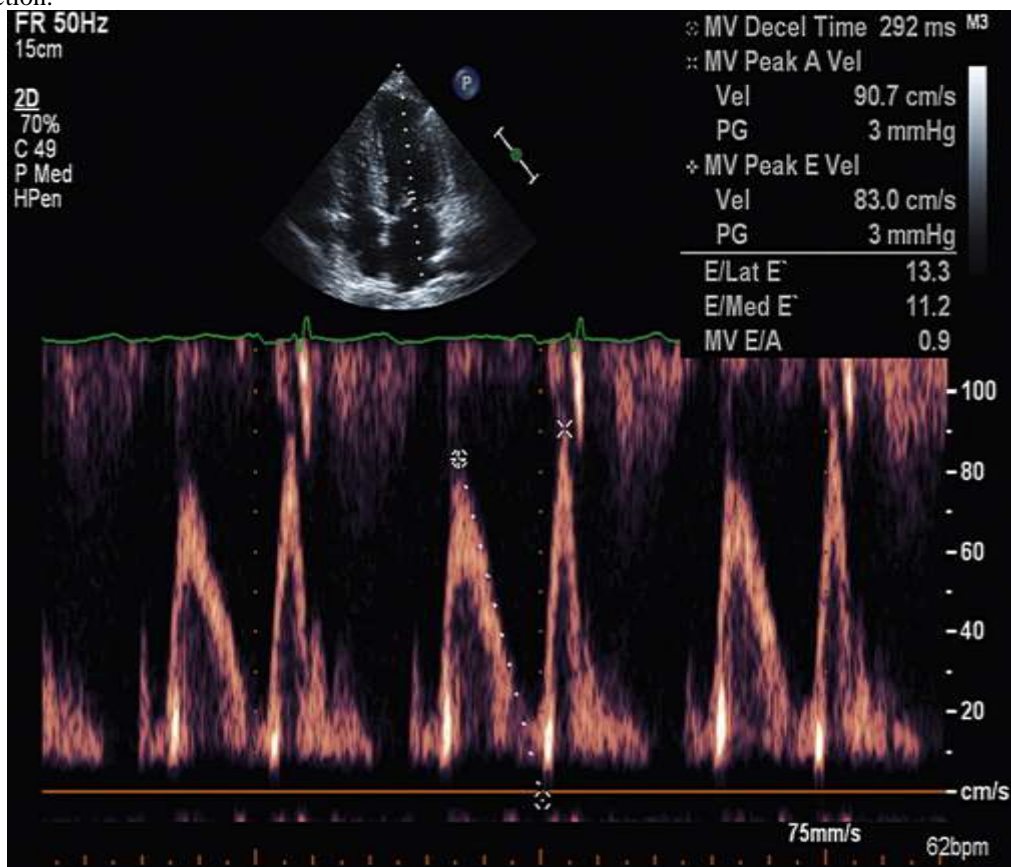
Trans mitral spectral Doppler demonstrating left ventricular inflow. The E and A waves are measures of atrial conduit and pump function, respectively (10).
